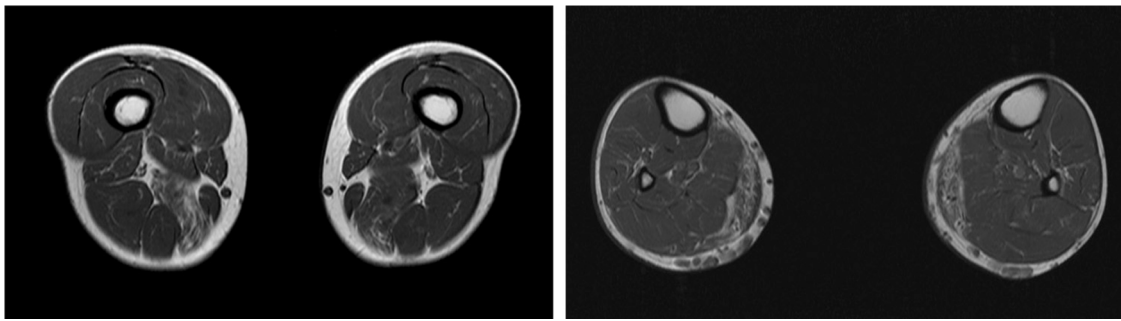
T1-weighted MRI scan of the thighs and calves, axial plane. Asymmetric fatty infiltration in the semimembranosus and medial gastrocnemius muscles.
